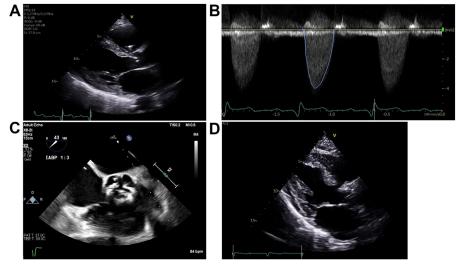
70-year-old presents with cardiogenic shock. (*A*) Parasternal long axis view shows severe left ventricular systolic dysfunction with thickened aortic valve leaflets. (*B*) Continuous wave Doppler shows a peak gradient of 63 mm Hg and a mean gradient of 37 mm Hg compatible with severe aortic stenosis. (*C*) Short axis transeso-phageal echo shows a trileaflet aortic valve with limited leaflet excursion. The patient was supported with an intra-aortic balloon pump (IABP) for cardiogenic shock. (*D*) The patient underwent transcatheter aortic valve replacement with a 26 mm Edwards S3 valve with improvement in left ventricular systolic function.
